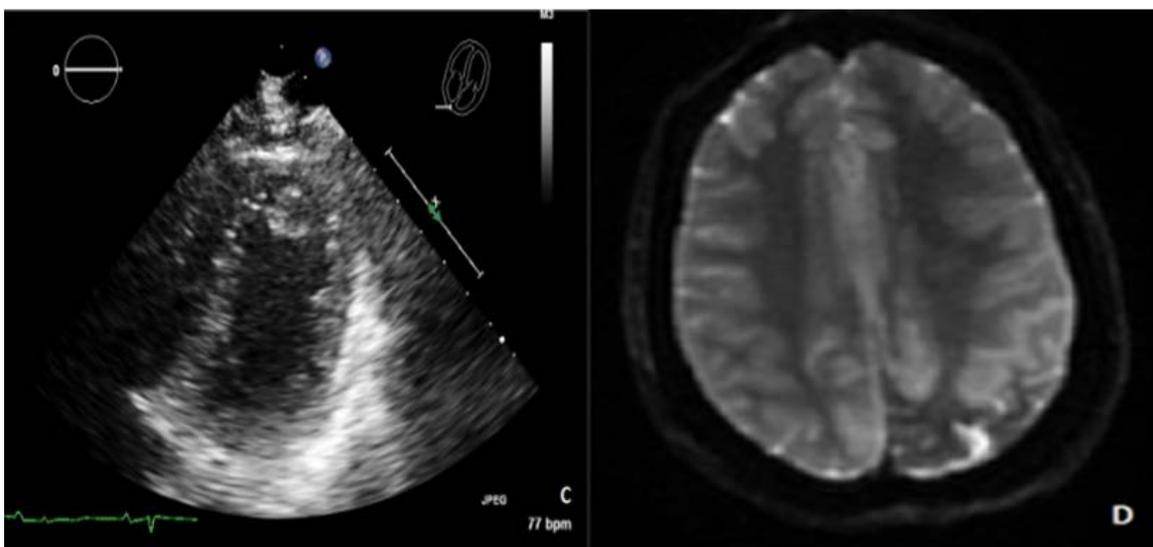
Transthoracic echocardiogram showing left ventricular hyperechoic structure probably thrombus versus mass. Figure D. Diffusion weighted imaging sequence from cranial magnetic resonance imaging demonstrates diffuse bilateral cerebral restricted diffusion compatible with infarction
